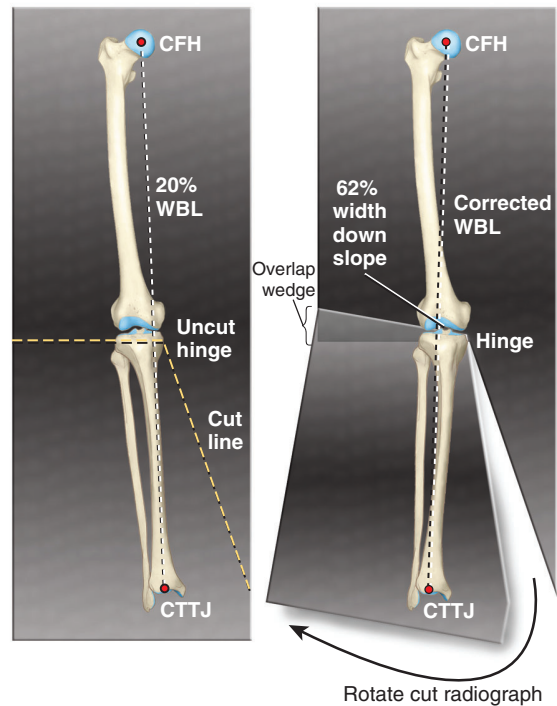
An alternative method used to calculate the correction angle of a high tibial osteotomy using a full-length anteroposterior radiograph of the lower extremity. The radiograph is cut to allow the center of the femoral head (CFH), the 62% coordinate, and the center of the tibiotalar joint (CTTJ) to become collinear. The angle of the resulting wedge of radiograph overlap equals the desired angle of correction. The example is provided for a closing wedge osteotomy. The same technique is used for an opening wedge osteotomy in which the medial tibial opening wedge is made to obtain the desired correction. *WBL*, Weight-bearing line.
